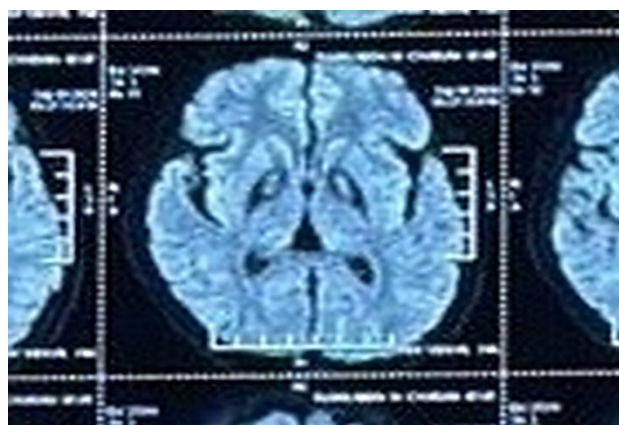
“Eye of the tiger sign” seen in MRI.
